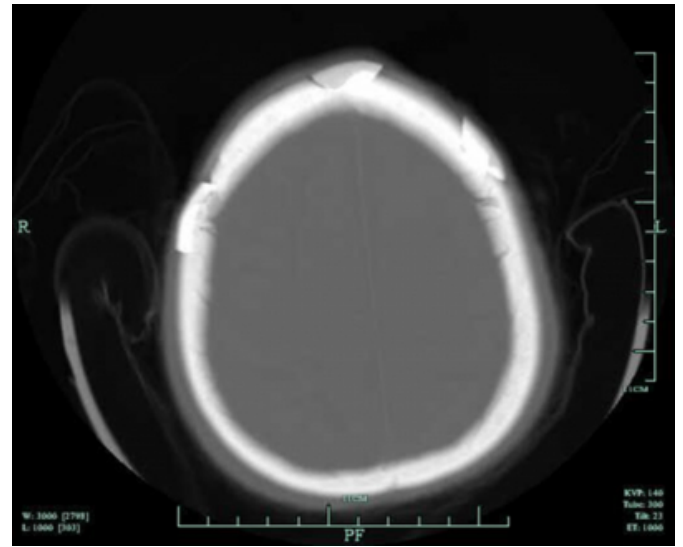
Non-contrast CT scan of the head (bony window)
